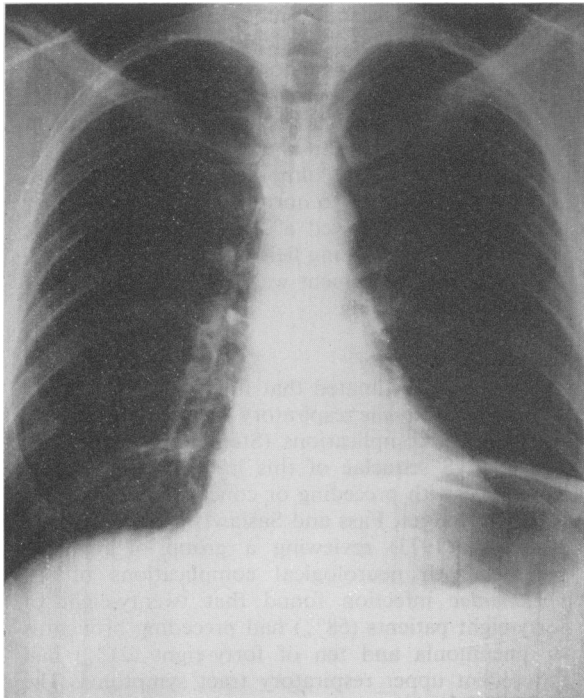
Chest X-ray showing clear lung fields with left hemidiaphragmatic elevation.
